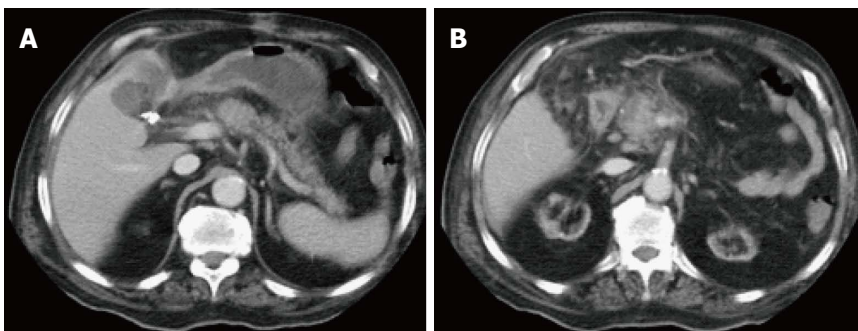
Focal pancreatic head necrotizing pancreatitis confined to the pancreatic parenchyma. A and B: Axial CT scan during the portal venous phase. There is evidence of significantly reduced enhancement of the pancreatic head (B), without peripancreatic extension or necrosis in keeping with focal acute necrotizing pancreatitis.
